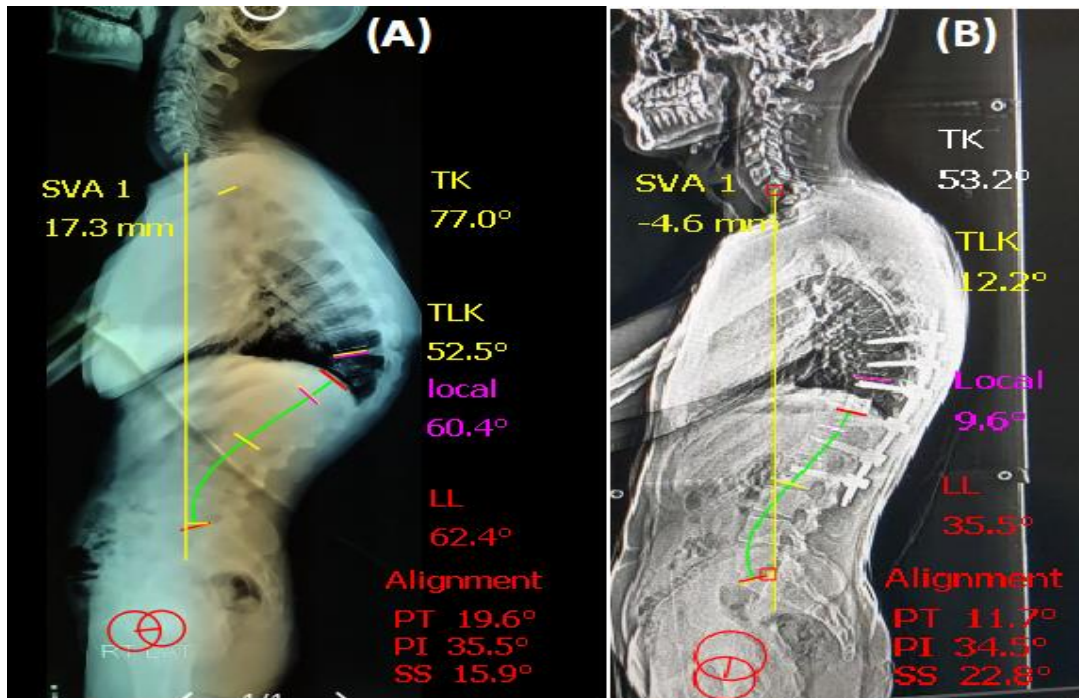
(A) longstanding X-ray sagittal view 18 months after T 11 fracture treated conservatively, (B): longstanding X-ray sagittal view 24 months after T 11 VCR showing sagittal parameters change.
